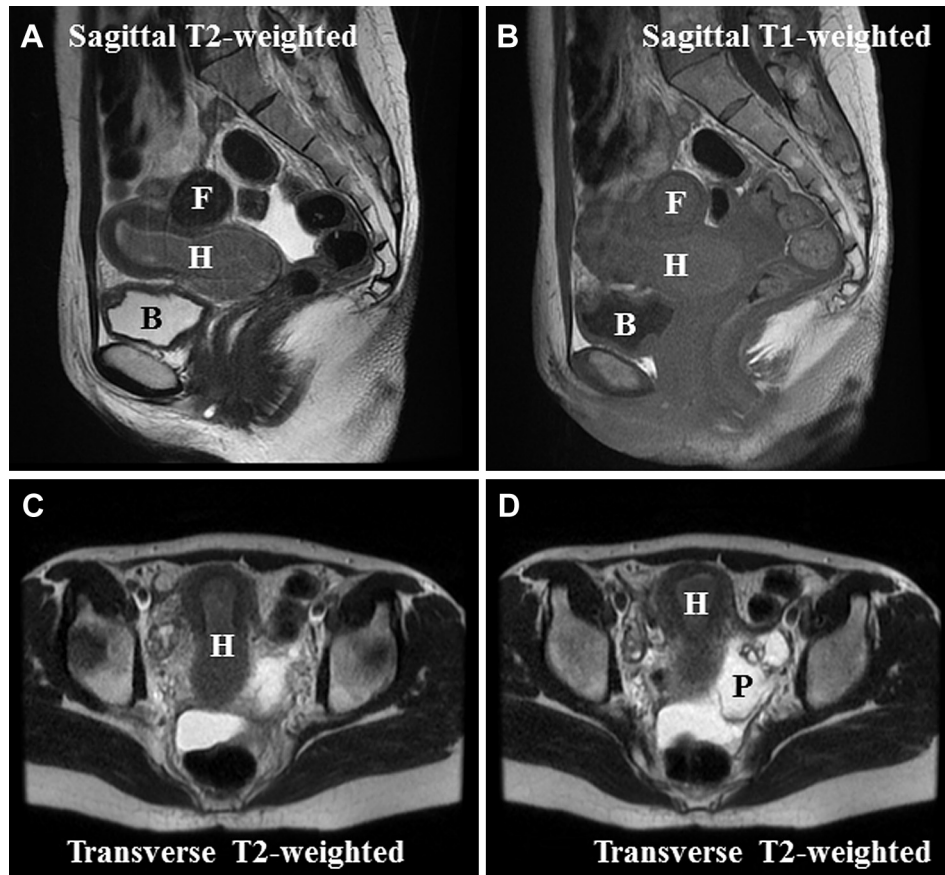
Findings of preoperative magnetic resonance imaging. (A–C) Magnetic resonance imaging clearly reveals a hematometra. Fluid collection in the uterine cavity demonstrated iso to mild high signal intensity on T2-weighted imaging and iso signal intensity on T1-weighted imaging. These findings are compatible with hyperacute hemorrhage. (D) Magnetic resonance imaging reveals the presence of a septate pseudocyst containing serous fluids in the pelvis probably caused by repeated inflammation because of retrograde menstrual blood. B = bladder; F = fibroid; H = hematometra; P = pseudocyst.
